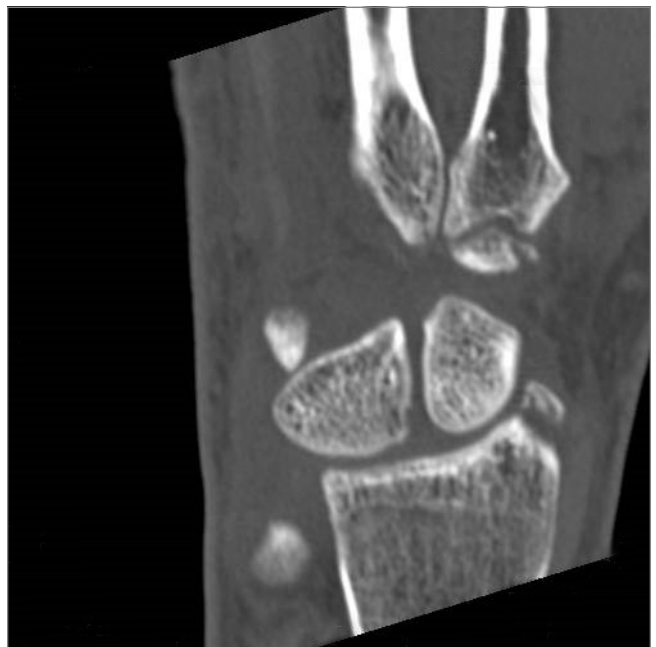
Computed tomography shows radial styloid fracture.
